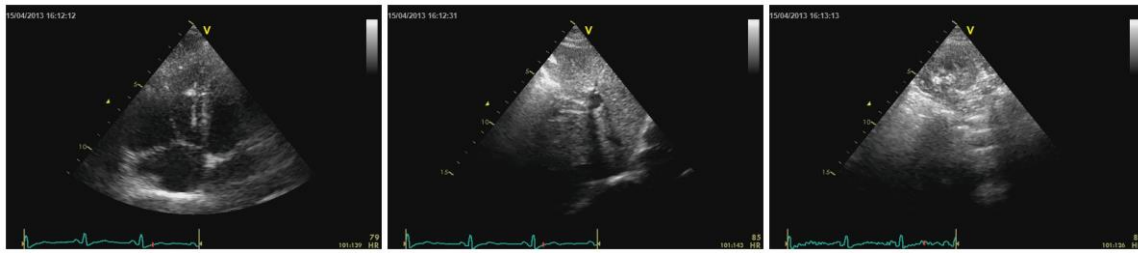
An example frame of some of the sequences used in the tests. Left to Right: (a) Echocardiography: 4 chambers view. The right ventricle is dilated. (b) Echocardiography: the subcostal view displays the liver and the inferior vena cava. (c) Renal ultrasound: cortical and medullary view.
